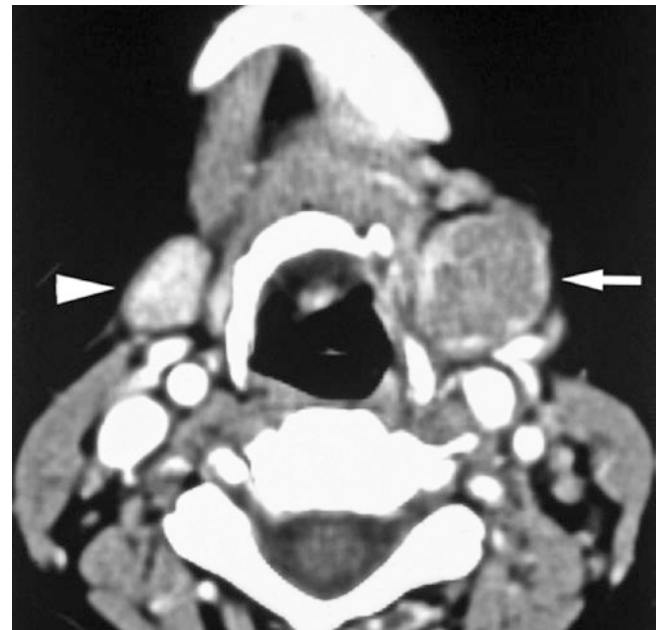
Submandibular gland non-Hodgkin's B-cell lymphoma; 56-year-old female with weight loss, poor general condition, and lump in submandibular region; no pathologic lymph nodes were found by surgery. Axial post-contrast CT image shows low-density mass with enhancing peripheral rim of the remaining parenchyma of the left submandibular gland (*arrow*), with normal right gland for comparison (*arrowhead*)
